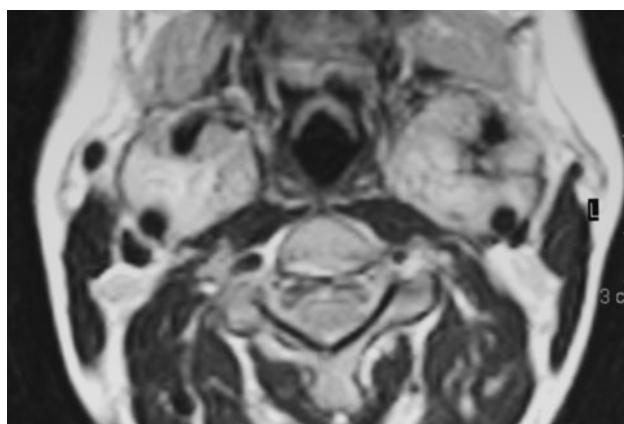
Bilateral tumors are seen on MRI at the level of carotid bifurcation with medialization of the oropharyngeal walls. The tumors encase the internal carotid arteries
